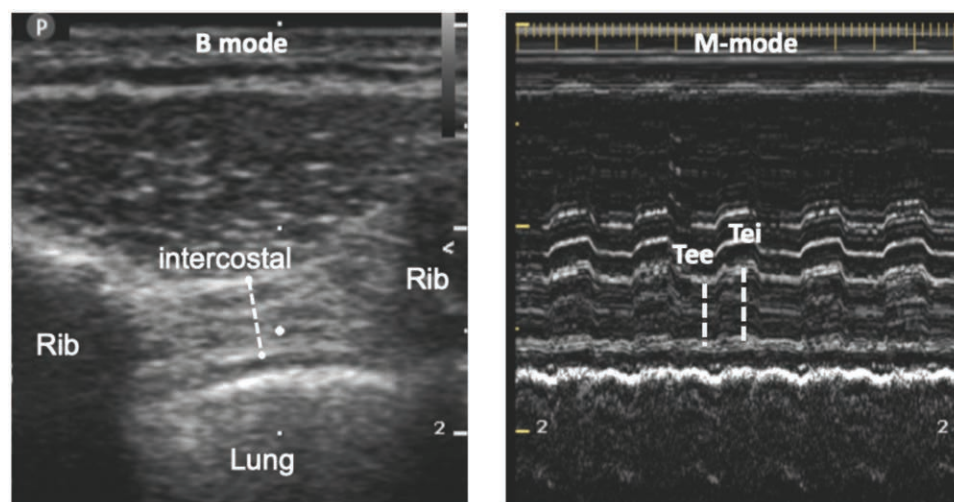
Ultrasound of the right parasternal intercostal muscle. (Left) The parasternal intercostal muscle was identified as a three-layered biconcave structure: two linear hyperechoic membranes respectively running from the anterior and posterior aspects of the adjoining ribs, and a medial portion with muscle echotexture. Measurement in B-mode was taken at the central, thinnest section of the muscle (dotted line). (Right) Using M-mode, the thickness of the parasternal intercostal muscle was measured on frozen images at end-expiration (Tee) and end-inspiration (Tei).
